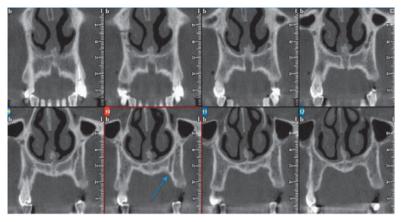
Detection of CS in coronal view of CBCT.
